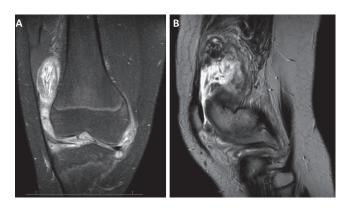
(a,b) – Coronal section of T2-weighted MRI (a) and sagittal section of T2-FS weighted MRI of the right knee demonstrating diffuse synovitis and free intra-articular bodies.
